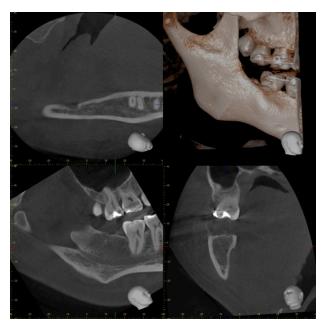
Six years postoperative CBCT.
